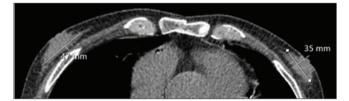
Computed tomography (CT) images showing axial diameter measurement of an 81-year-old patient with bilateral gynecomastia
